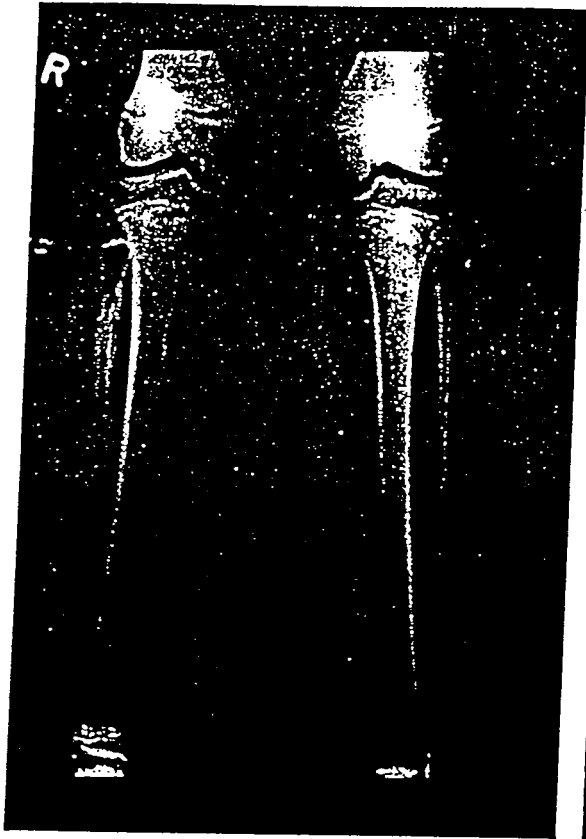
X-ray (14 Dec. 1984) after eleven months of Ukrain therapy.
